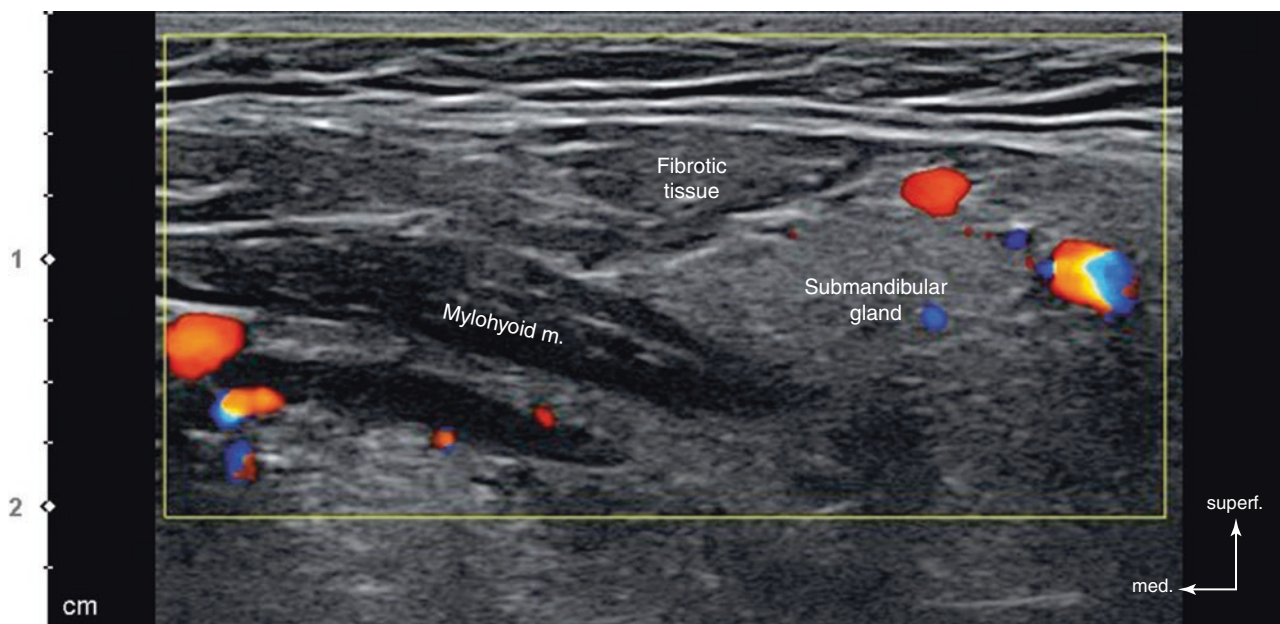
Ultrasonography of the partial fibrosis of the submandibular gland, Doppler mode (transverse view, 15 MHz by linear transducer). (Published with kind permission of © Ji-Soo Kim 2020. All Rights Reserved)
